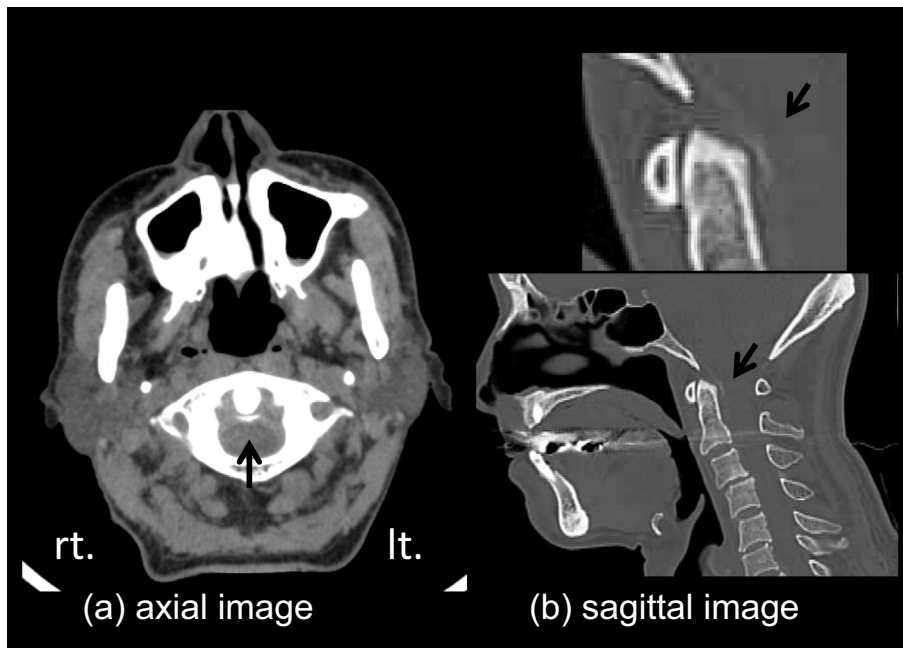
Cervical CT of the odontoid process (dens): (a) axial and (b) sagittal images show calcification of the transverse ligament of the atlas.
